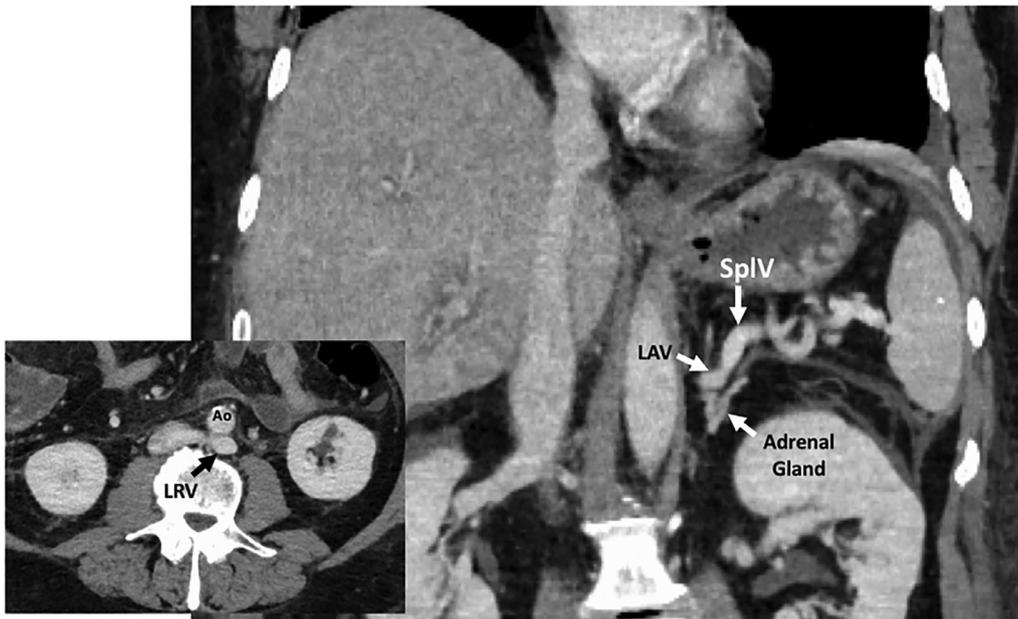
Coronal computed tomography postoperative image of a variation of the distal splenorenal shunt of Warren; the splenic vein was sutured end-to-end into the left adrenal vein. This variation was created because of an anomalous retroaortic location of the left renal vein (image inset), which created too severe of an angulation to complete a standard distal splenorenal shunt. This patient's inferior mesenteric vein drained into the superior mesenteric vein. Ao = aorta; LAV = left adrenal vein; LRV = left renal vein.
